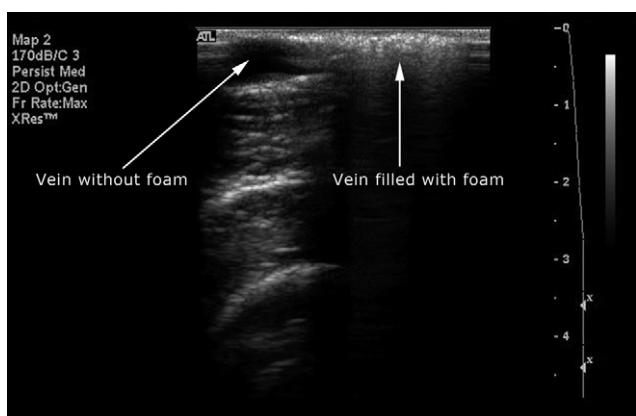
The visibility of foam with ultrasound makes accurate placement possible. Photographed by Terry Williams, RVT, and Eric Mowatt-Larssen, MD, and adapted from Mowatt-Larssen E, Shortell C, Desai S: *Clinical Review of Phlebology and Venous Ultrasound*. Durham, NC, Surgisphere Corporation, 2012,³⁸ with permission.
